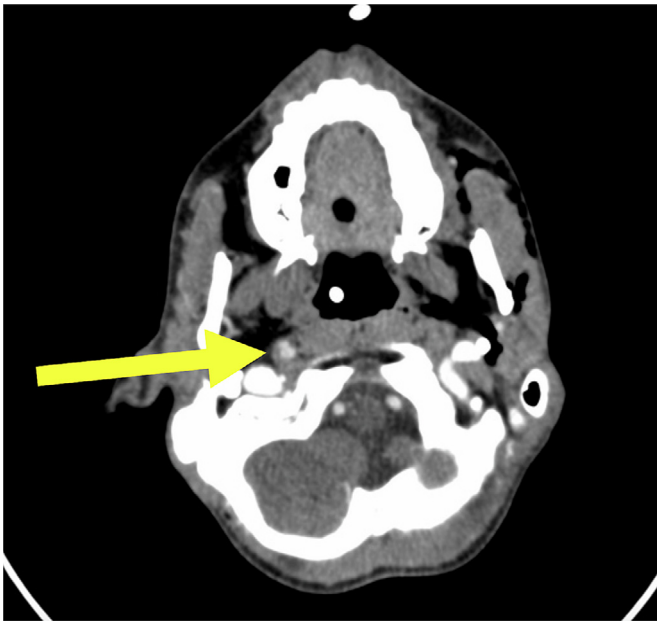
CTA demonstrating crescent-shaped hyperattenuating focus on the right internal carotid artery (ICA), representing intramural hematomas, with an intimal flap and double-lumen (yellow arrow). Case courtesy of Antonio Rodrigues de Aguiar Neto, Radiopaedia.org, rID: 96007.
